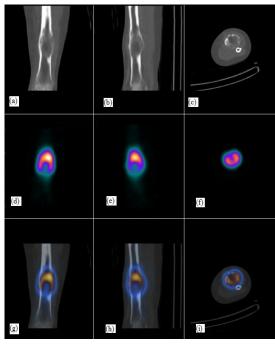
(a) CT, (b) SPECT and (c) fused SPECT-CT images showing a focus of increased tracer accumulation at the diaphysis of left distal tibia which correspond to a lytic lesion with cortical destruction, periosteal reaction and pathological fracture.
